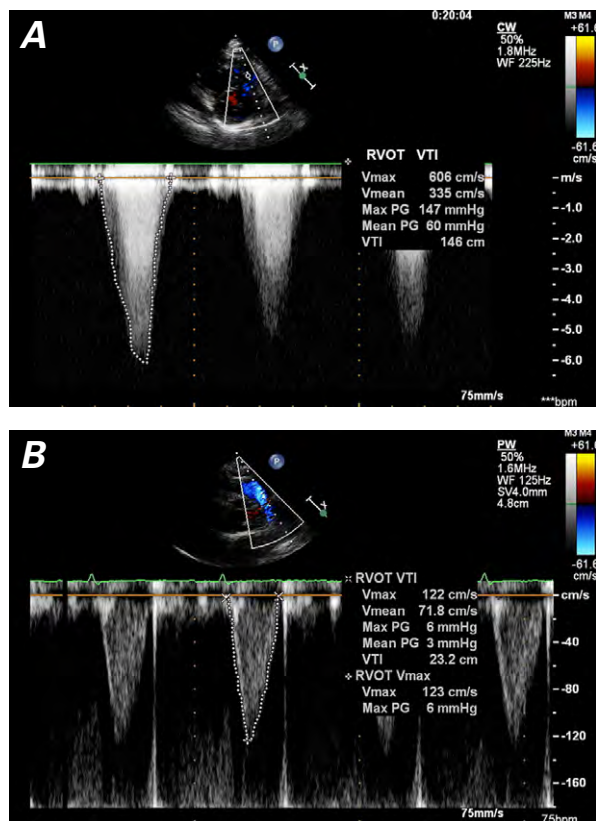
Transthoracic echocardiograms show A) severe preoperative right ventricular outflow tract (RVOT) obstruction (RVOT Vmax=6 m/s) and B) the postoperative peak right ventricular gradient of 6 mmHg (mean gradient, 3 mmHg).
